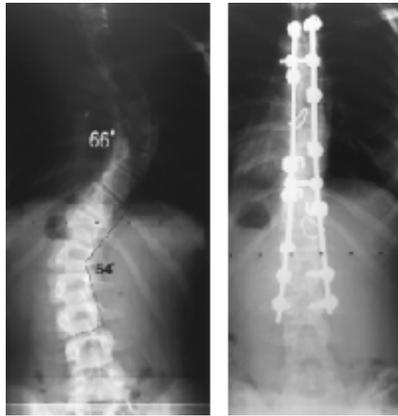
A standing posteroanterior radiograph of the spine is the correct film to use in quantitating the magnitude of scoliosis. A: The Cobb method of measurement is used routinely and is obtained as shown on this radiograph. B: The postoperative result after spinal correction and fusion in the same patient.
